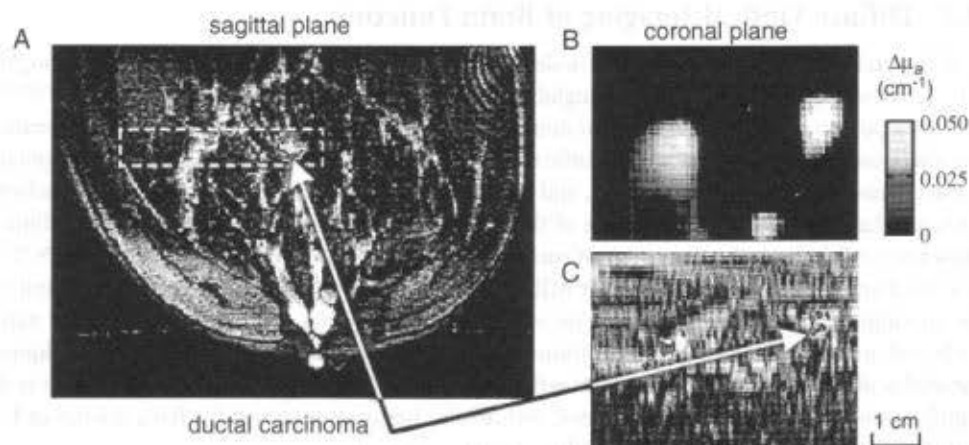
(Color figure follows p. 28-30.) A dynamic MRI and contrast-enhanced DOT image of a ductal carcinoma. (A) A dynamic sagittal MR image after Gd contrast enhancement passing through the center of the malignant lesion. (B) The coronal DOT image, perpendicular to the plane of the MRI image in (A), but in the volume of interest indicated in (A) by the dashed-line box. (C) The dynamic MR coronal image resliced from the same volume of interest and same dimensions as (B).
